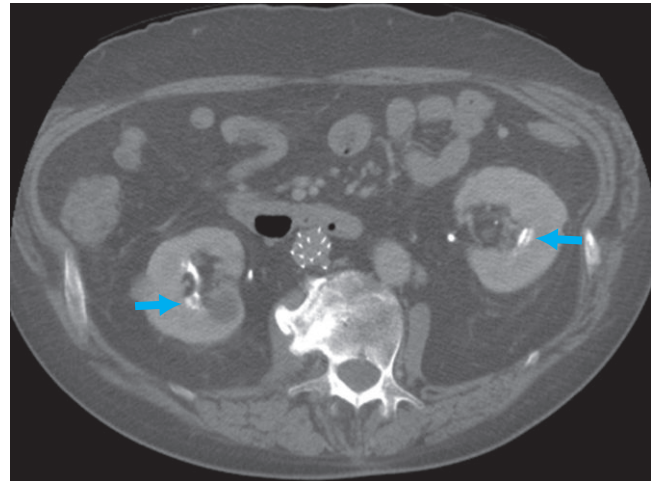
Image from CT urogram in a different patient demonstrates "paint brush" appearance of the renal pyramids (arrows) secondary to tubular ectasia seen with medullary sponge kidney.
